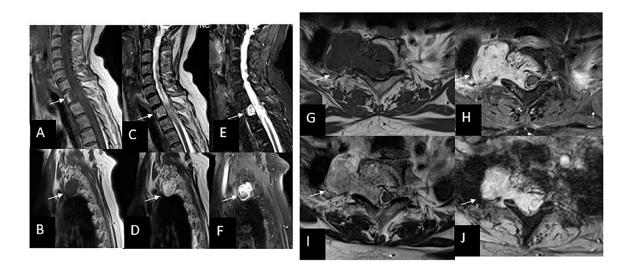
Baseline MRI showing the dumbbell-shaped epidural and paraspinal mass at the right T1-T2 level, with arrows highlighting the site of the disease. T1-TSE on (A) sagittal midline, (B) right parasagittal, and (G) axial planes; T2-TSE on (C) sagittal midline, (D) right parasagittal, and (I) axial planes; (E) T2-STIR at midline; T1-TSE fat-sat postgadolinium on (F) right parasagittal, and (H) axial planes; and (J) T2-MEDIC on axial plane.
